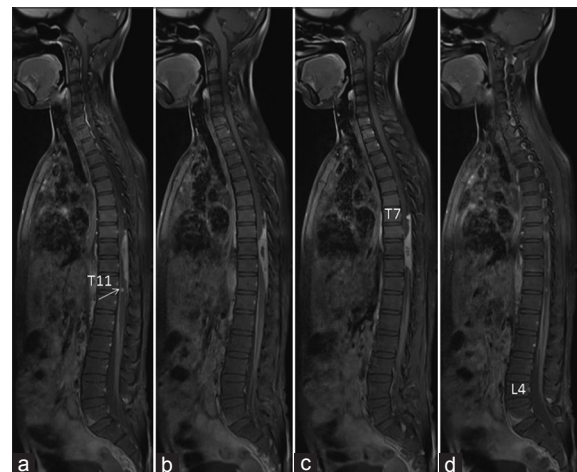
(a-d) MRI whole spine - post-gadolinium T1 weighted sagittal sequence showing a dorsally placed T7-T11 IDEM lesion with thin enhancing layer of it extending down till L4 body level. A small enhancing intramedullary lesion at T11 body level is also seen (white arrow). Vertebrae and disk spaces are normal. There was no extradural or paraspinous extension
